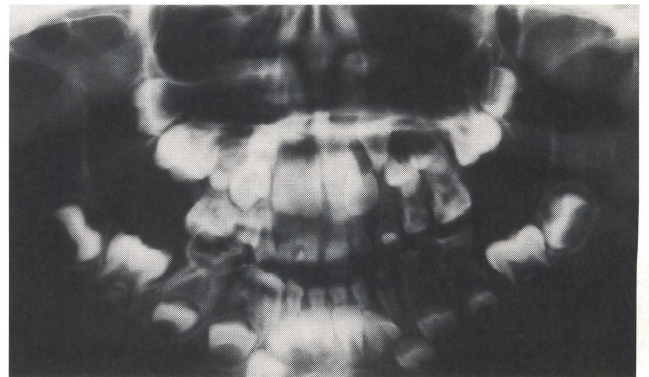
Orthopantomogram showing widespread dental caries, the presence of all forming permanent teeth with the exception of third molars, separation of the crowns of 22 and the enlarged 21, and a rotated 23.
